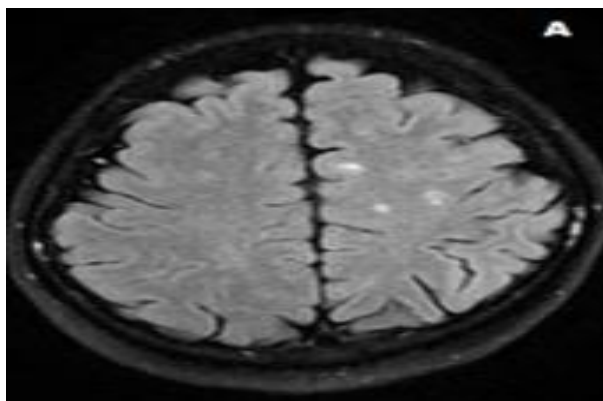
Axial FLAIR (A) showed multiple hyperintense foci distributed on both high parietal regions, (B) showed hypointense area of cerebrospinal fluid like signal in right caudate nucleus, axial diffusion-weighted imaging (C-D) showed no diffusion restriction, (E) fractional anisotropy map and (F) corticospinal tractography showed decrease in fiber density of left corticospinal tract in comparison to the right side with fractional anisotropy 0.431
